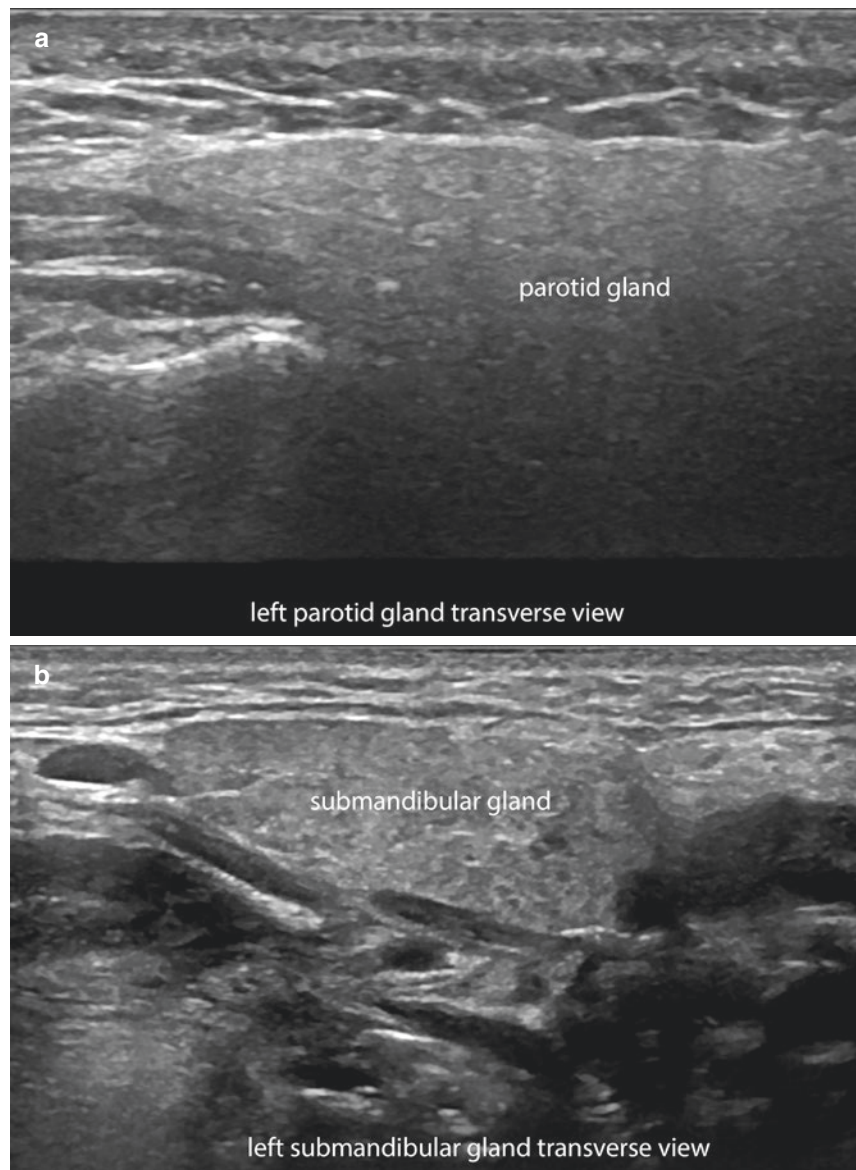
Ultrasound morphology of salivary glands. (a) Parotid gland (transverse view). (b) Submandibular gland (transverse view). (c) Minor salivary submucosal gland at the lower lip (between markers; longitudinal view). Notice the homogeneity of the glands, mostly hyperechoic in the parotid and submandibular glands and hypoechoic in the minor salivary glands.
